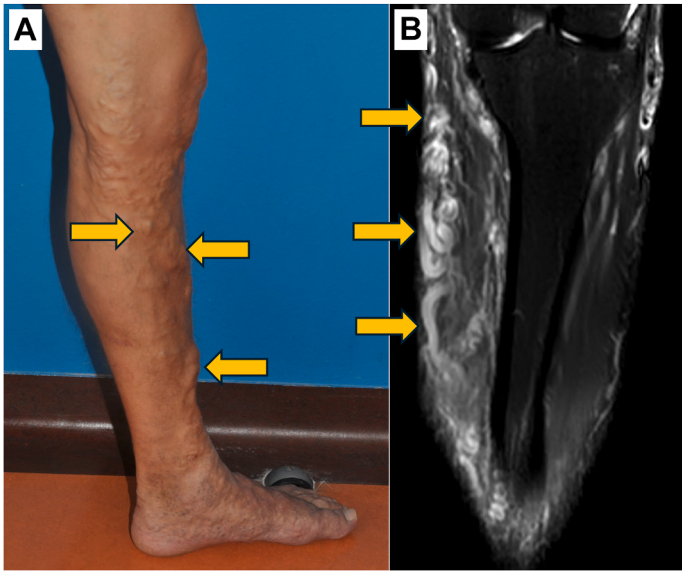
(A, B) (A) Male patient with diffuse phlebectatic VM of left leg with an ectatic vein component (orange arrows). (B) T2-weighted MRI of the affected leg with subcutaneous tortuous and dilated veins (orange arrows).
